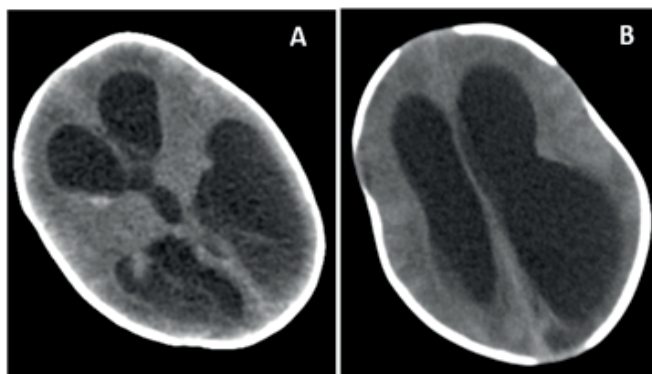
Preoperative axial CT scan of hemorrhage at the posterior frontal horn of right lateral ventricle (A) and dilated third, fourth and lateral ventricles (B)
